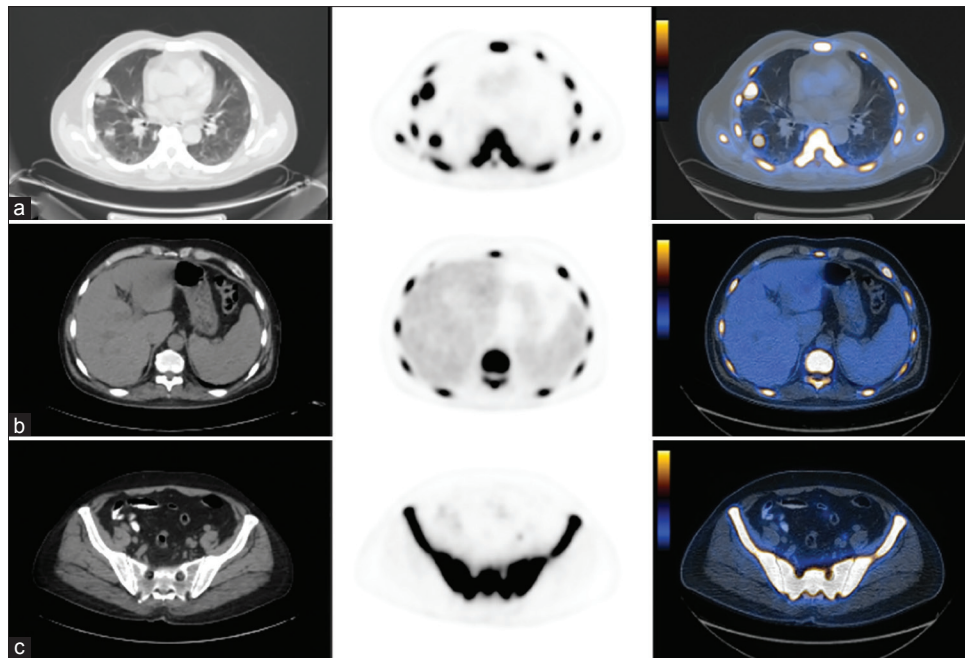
CT (left), PET (middle) and fused PET/CT (right) slices of ¹⁸F PET scan from thorax (a), upper abdomen (b) and pelvis (c)
